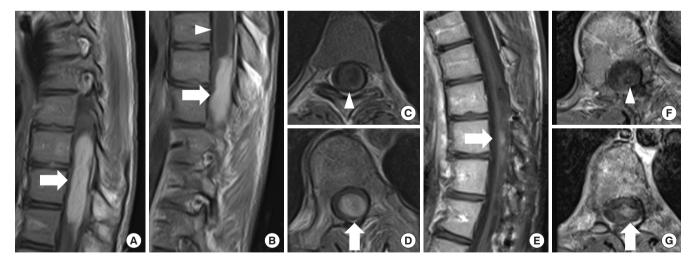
Pilocytic astrocytoma, World Health Organization grade 1. (A–D) An 18-year-old man scheduled for surgery for scoliosis revealed a mass lesion at T8–12 with syrinx. The tumor was shown in contrast by gadolinium-enhanced T1-weighted magnetic resonance imaging (MRI) (arrow: tumor, arrowhead: syrinx). During the waiting period for surgery, the patient suffered from sudden onset of paralysis of the lower limbs and urinary retention, and emergency surgery was performed. The tumor had a relatively distinct surgical plane that separated it from the surrounding spinal cord parenchyma, and almost the entire tumor could be removed. Thirty-one months later, MRI showed that a tiny contrast-enhancing lesion was still present (E, G) and the syrinx resolution (F). At 40 months postoperatively, the patient's neurological symptoms were stable.
